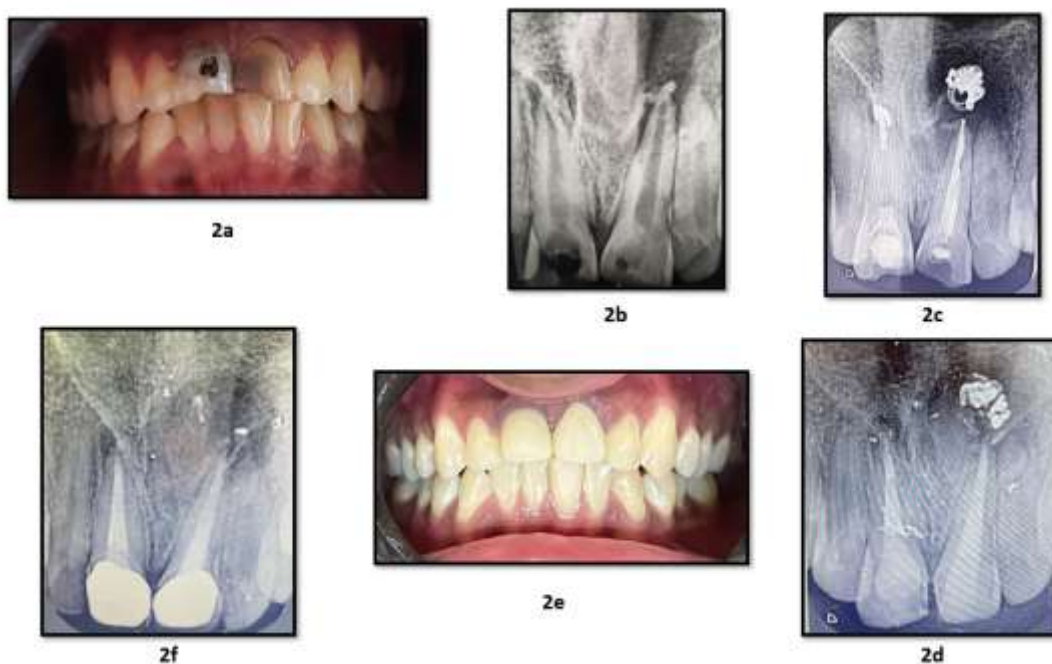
(2a) Clinical picture showing maxillary anterior discolored teeth, (2b) Radiographic representation of maxillary central incisors with periapical radiolucency (2c) Radiographic
